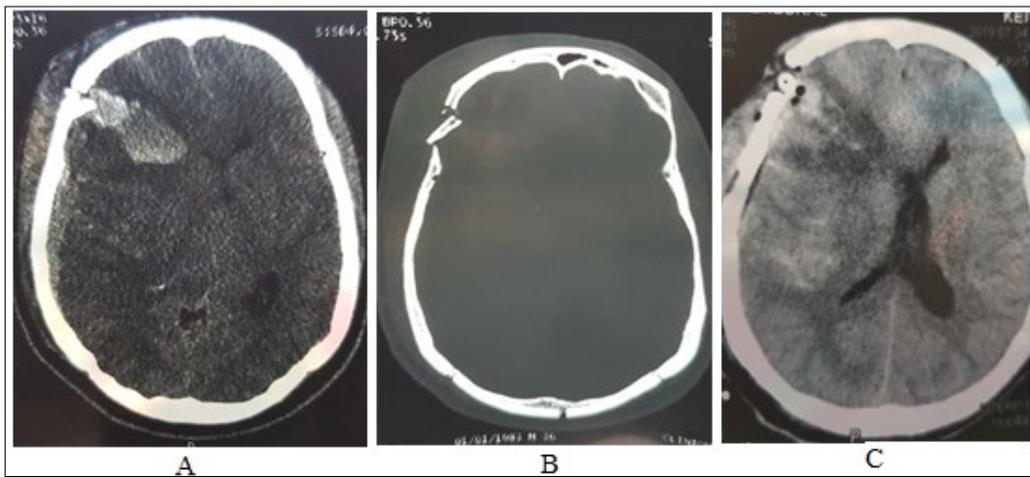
Cranio-encephalic CT: a) Parenchymal window: right frontal contusion with hematoma under dural acute; b) Bone window: frontal embarrure; c) Postoperative control.
